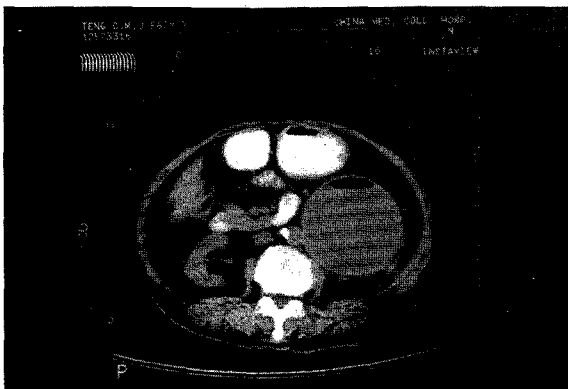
Abdominal computed tomography showing a huge cyst with air fluid level on the left kidney.
